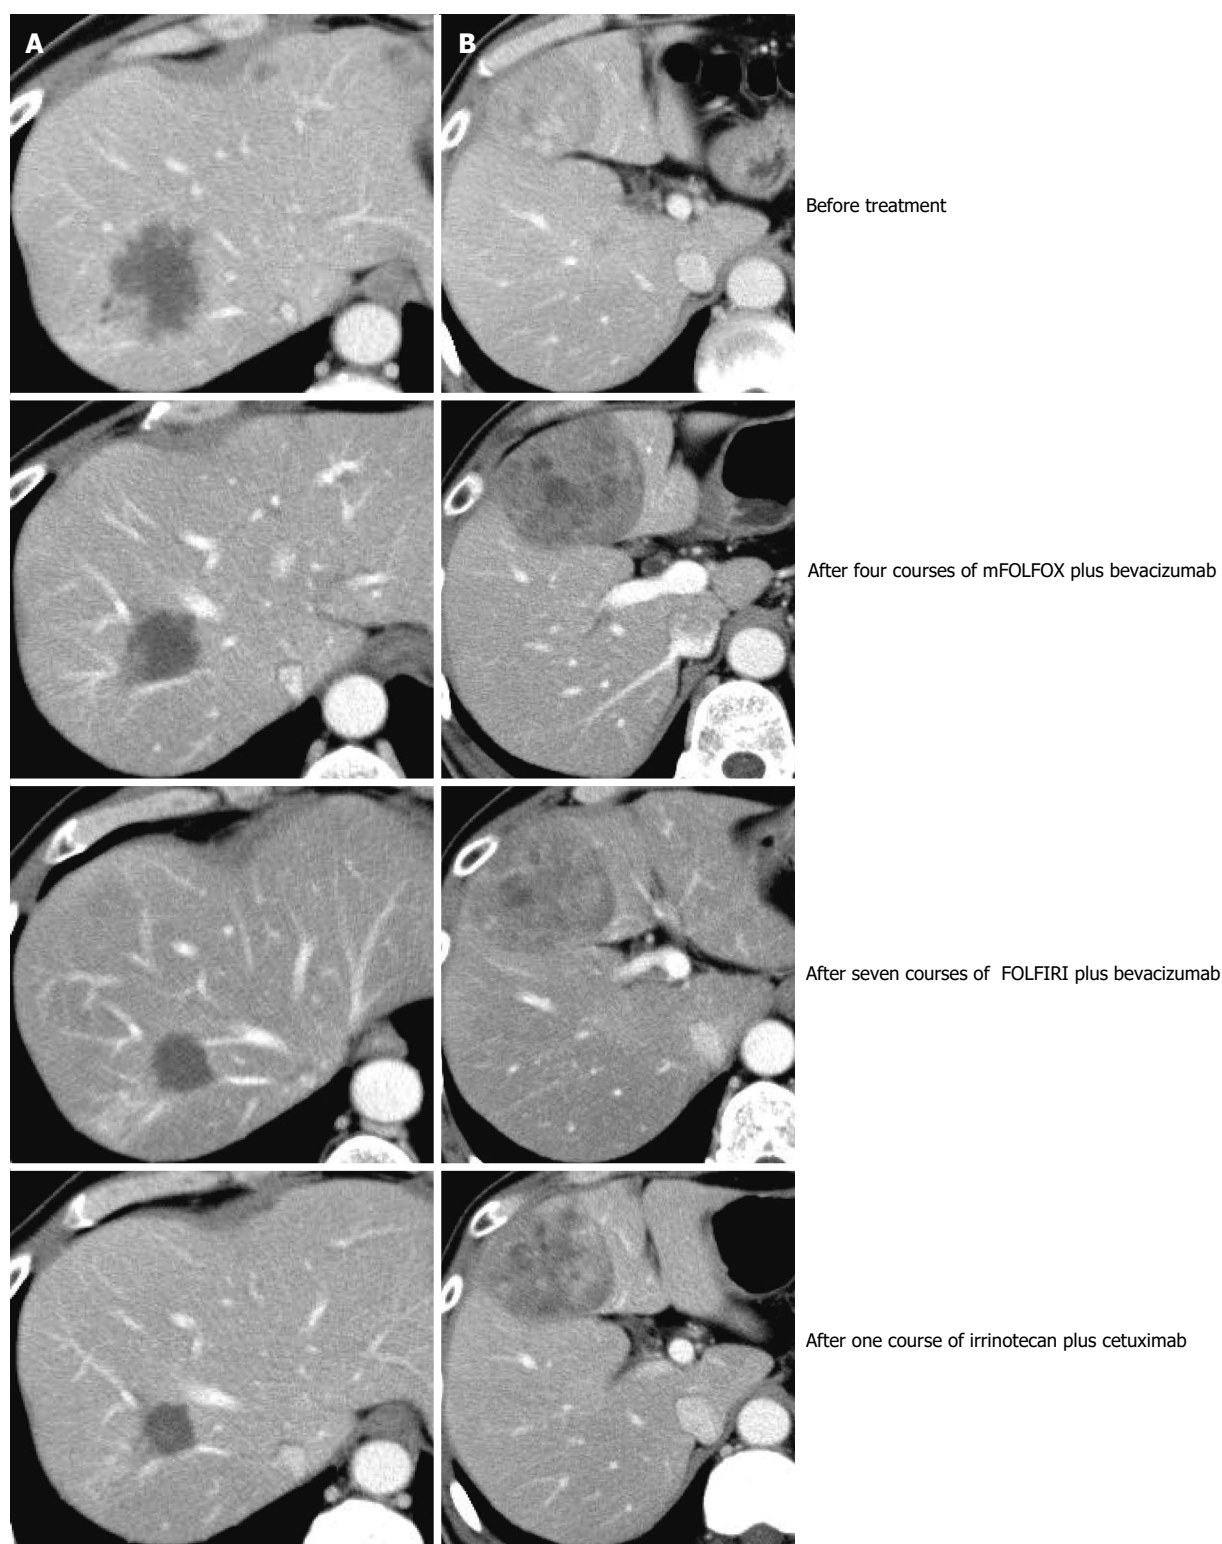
Changes in computed tomography images during treatment. The tumors in Segments 3 and 8 showed a gradual decrease in size, while the tumor in Segment 4 exhibited a one-time increase and then a decrease in size. A: S8 gradually decreased in size/S3 disappeared; B: S4 once increased then decreased in size.
